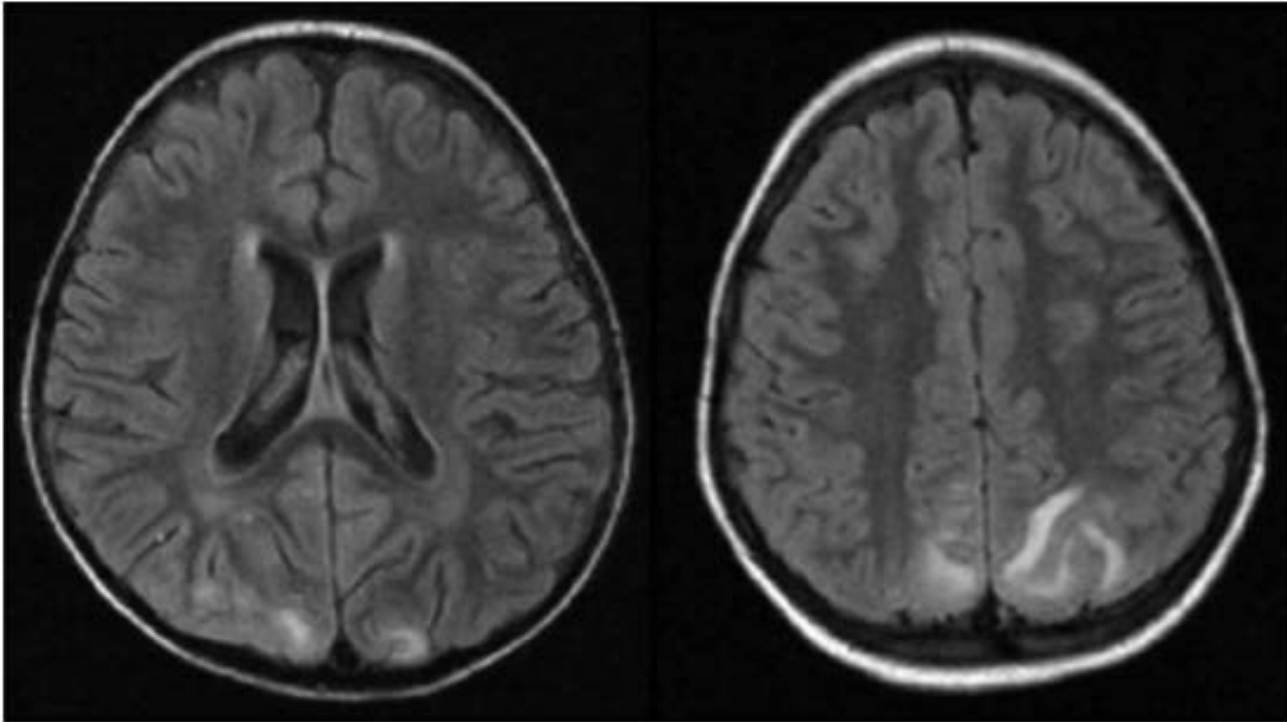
Brain magnetic resonance imaging (FLAIR) showing an increase of signal in both parieto-occipital lobes.
